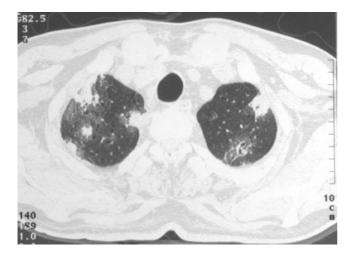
Invasive pulmonary aspergillosis in a 39-year-old man with acute myelogenous leukaemia and neutropenia. Thin-section CT at the level of the lung apex shows multiple nodules surrounded by a halo of ground glass opacity in both upper lobes.
